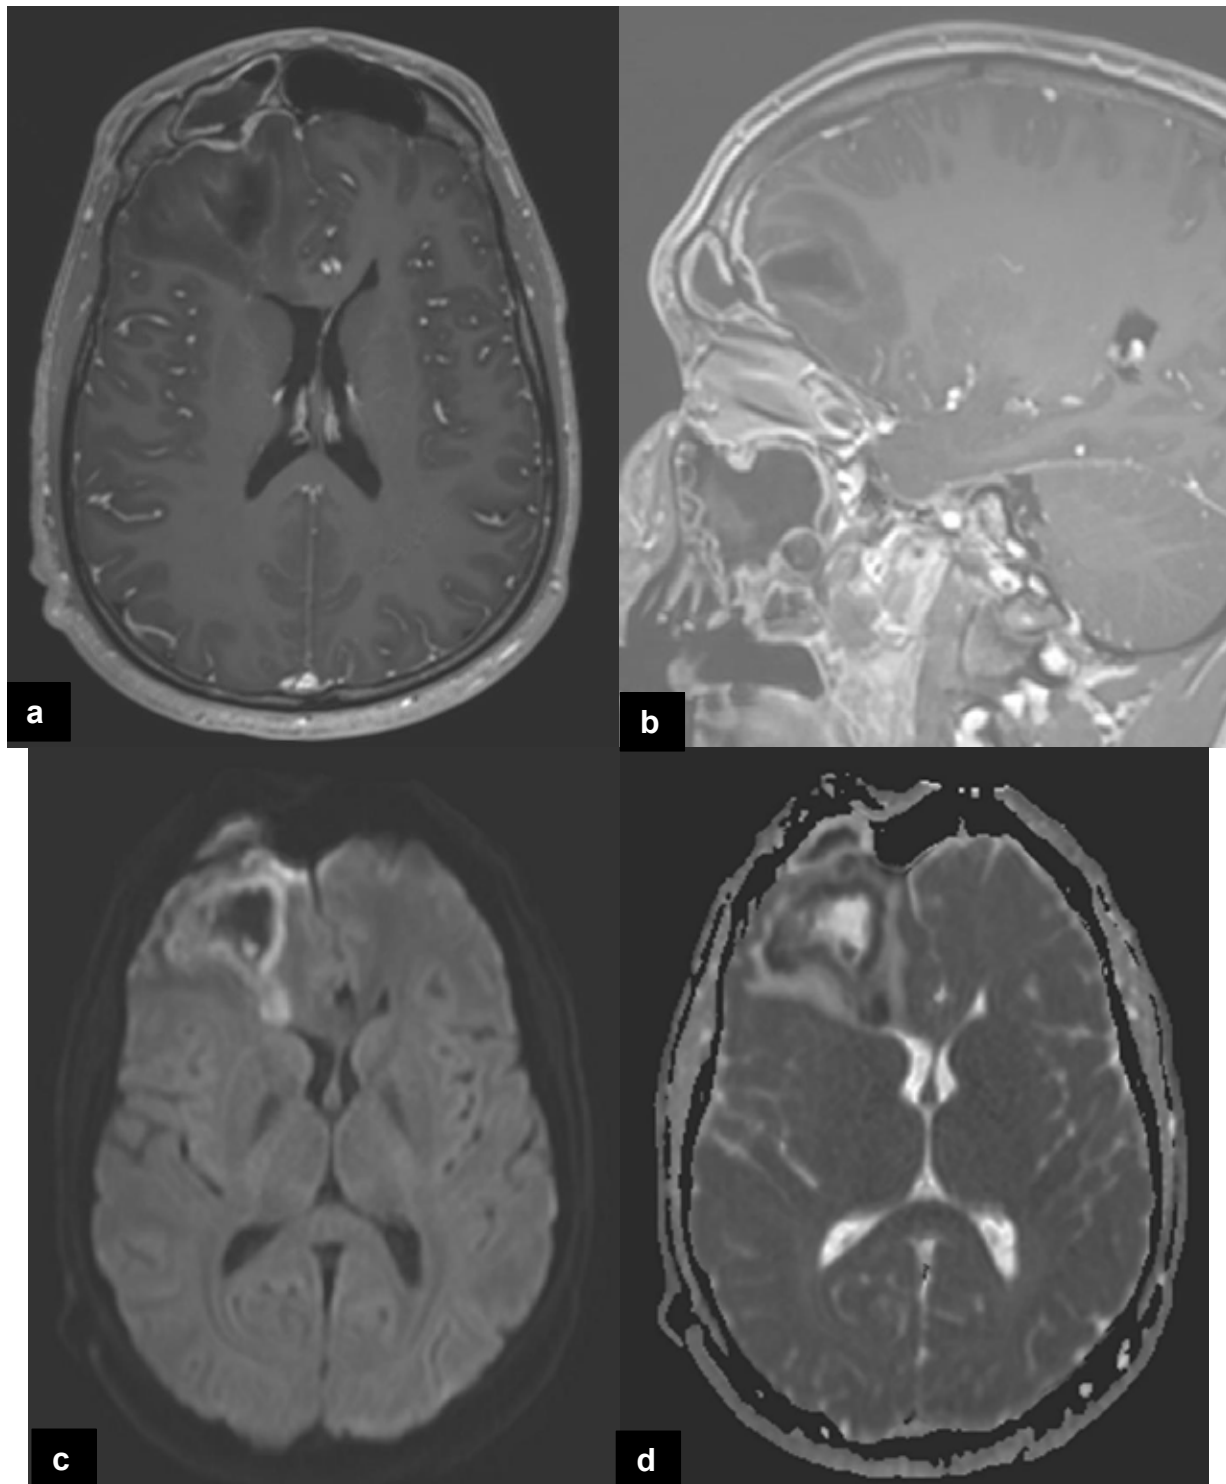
Right frontal thin extraaxial fluid collection, adjacent to the right frontal sinus, surrounded by thickened, strongly enhancing dura on axial (a) and sagittal (b) T1-weighted images, with signs of restricted diffusion on DWI (c) and ADC (d), corresponding to empyema. Signs of restricted diffusion in the abscess, corresponding to late cerebritis stage (c, d). Maxillary sinusitis (b).
